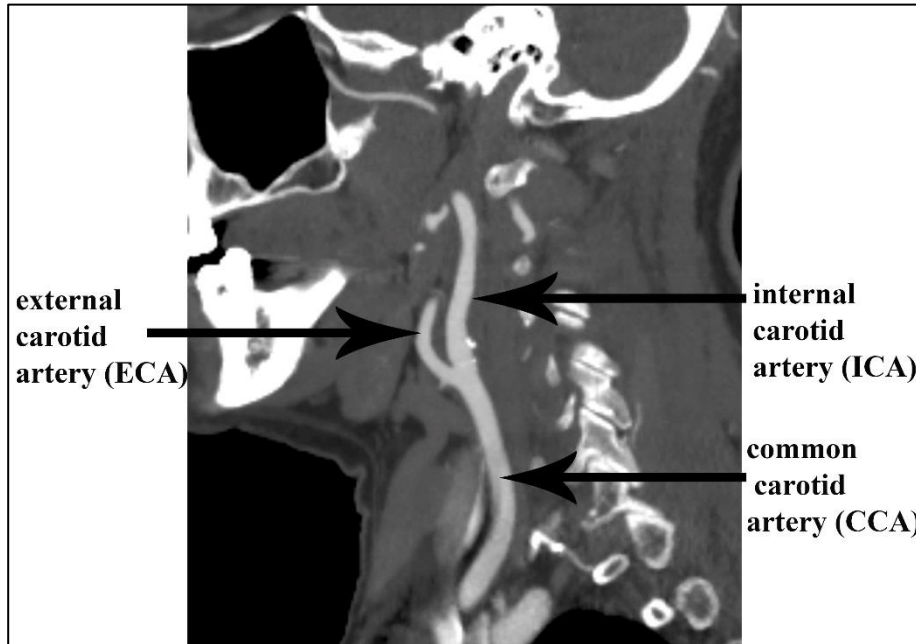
Computed Tomography Angiogram (CTA)
